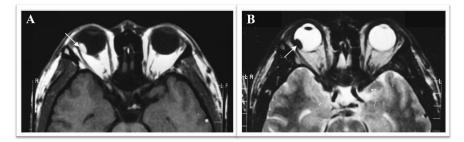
Axial Orbital MRI Images of Choroidal Melanoma. A) High signal on T1WI (arrow). B) Low signal on T2WI (arrow).
